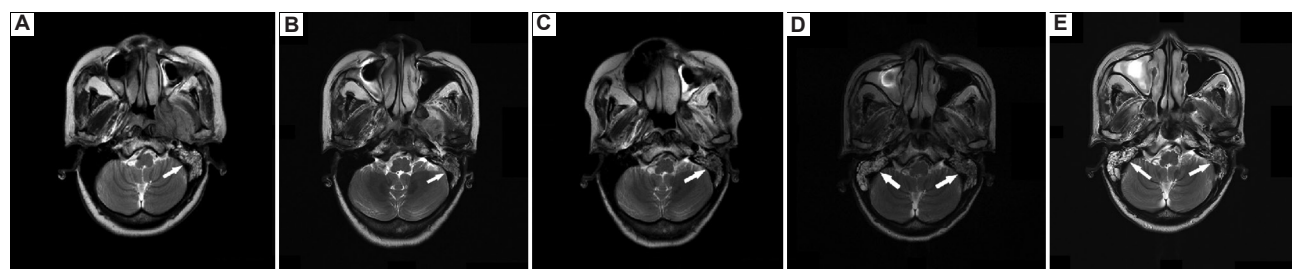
Axial T2-weighted MRI of an adult patient with biopsy-proven nasopharyngeal carcinoma revealing grade 3 mastoiditis (indicated by the white arrow) over the course of time: before NACT (A), before CCRT (B), and at 0 (C), 3 (D), and 6 (E) months after CCRT in conjunction with anti-PD-1 therapy.
